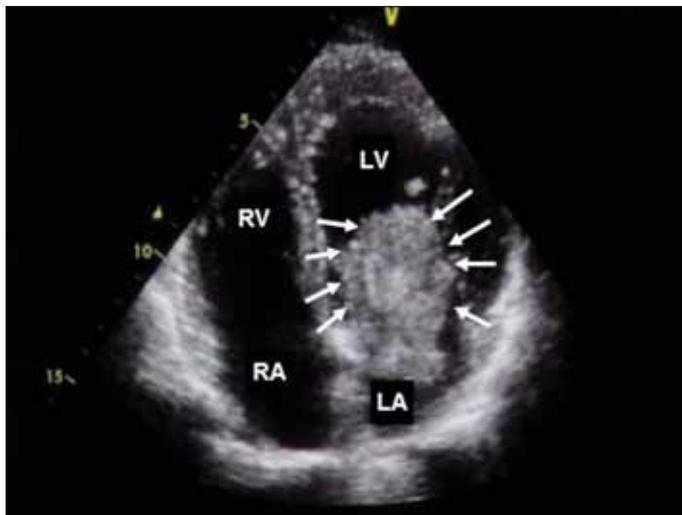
Apical 4-chamber echocardiographic view showing enlarged left atrium with large myxoma and mobile structure falling into left ventricle during diastole (see arrows)
